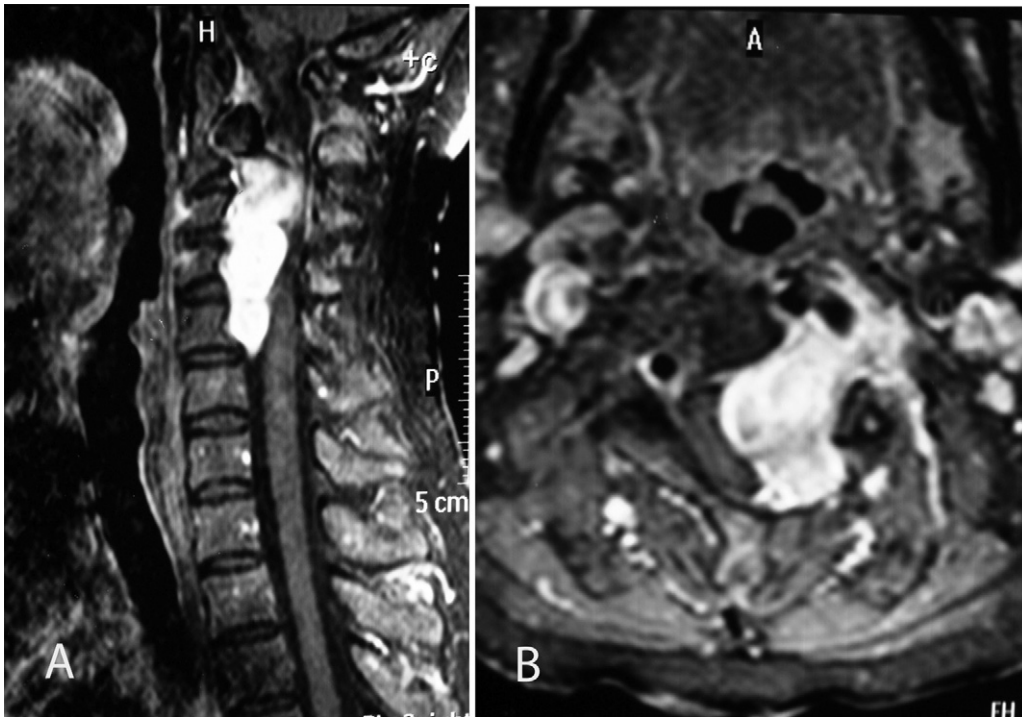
Magnetic resonance imaging of the cervical spine revealed an intradural, extramedullary, diffusely enhancing mass extending from vertebrae C2 to C6. (A) Preoperative sagittal T1-weighted magnetic resonance imaging demonstrating an extensive intradural upper cervical mass. (B) An intradural mass suggestive of a schwannoma in the upper cervical cord demonstrating compression of the cord laterally. The mass extends into the left neural foramen in the axial T1-weighted image.
